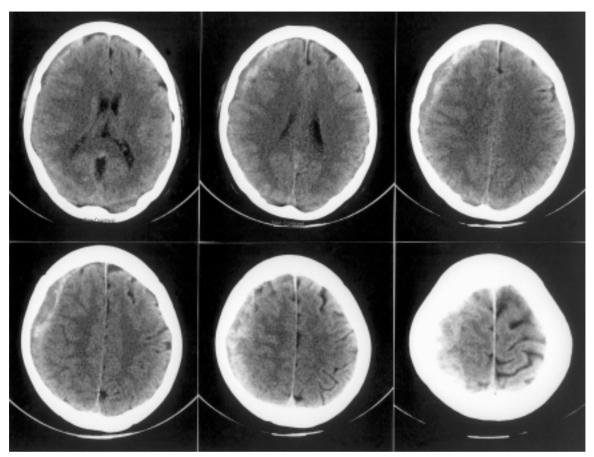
CT scan of brain without contrast enhancement 12 weeks after head injury shows a chronic subdural hematoma over right fronto-parietal lobe, brain swelling, and midline slightly shifting to the left.
